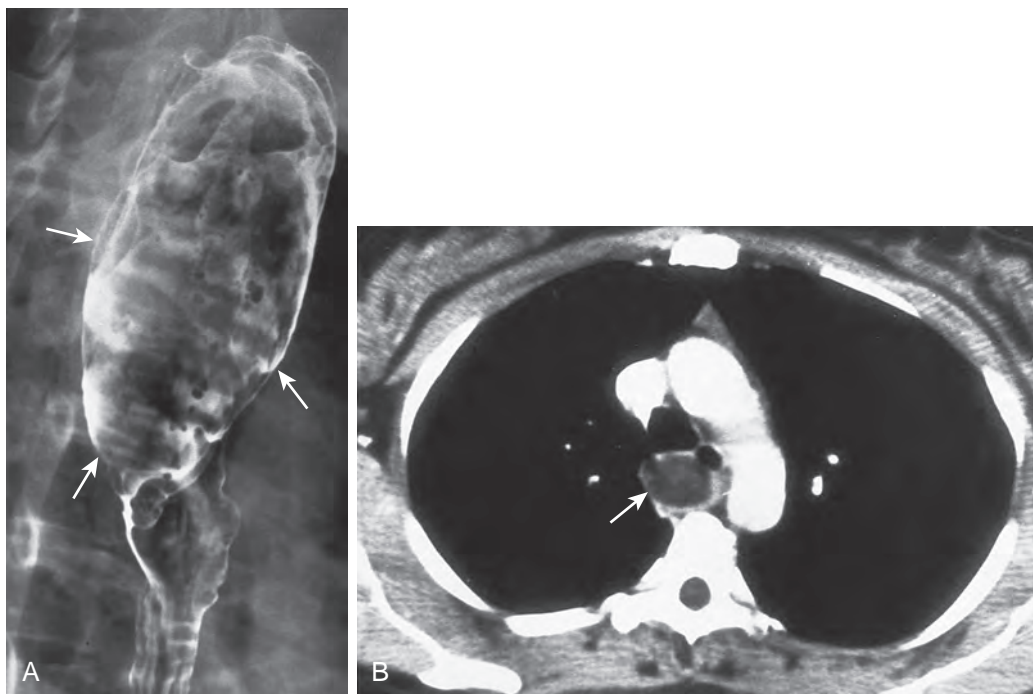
Fibrovascular polyp. A. Barium study shows a smooth, sausage-shaped mass (arrows) expanding the lumen of the upper thoracic esophagus. This lesion has the classic appearance of a fibrovascular polyp. B. Axial CT scan shows an expansile mass (arrow) in the thoracic esophagus with a thin rim of contrast material surrounding the lesion, confirming its intraluminal location. The fat density of the polyp is caused by an abundance of adipose tissue in this lesion. (From Levine MS, Buck JL, Pantongrag-Brown L, et al: Fibrovascular polyps of the esophagus: Clinical, radiographic, and pathologic findings in 16 patients. *AJR* 166:781-787, 1996.)
